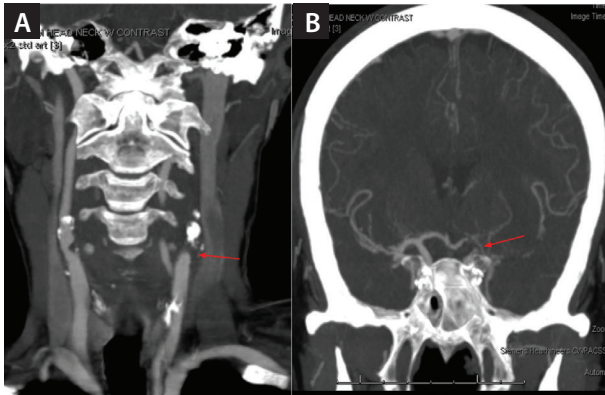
Coronal CTA of the neck demonstrating calcified plaques at the origin of both ICAs with occlusion of the left ICA at its origin (A). Coronal CTA of the head demonstrating occlusion of the left ICA summit at the origin of the left MCA (B).
